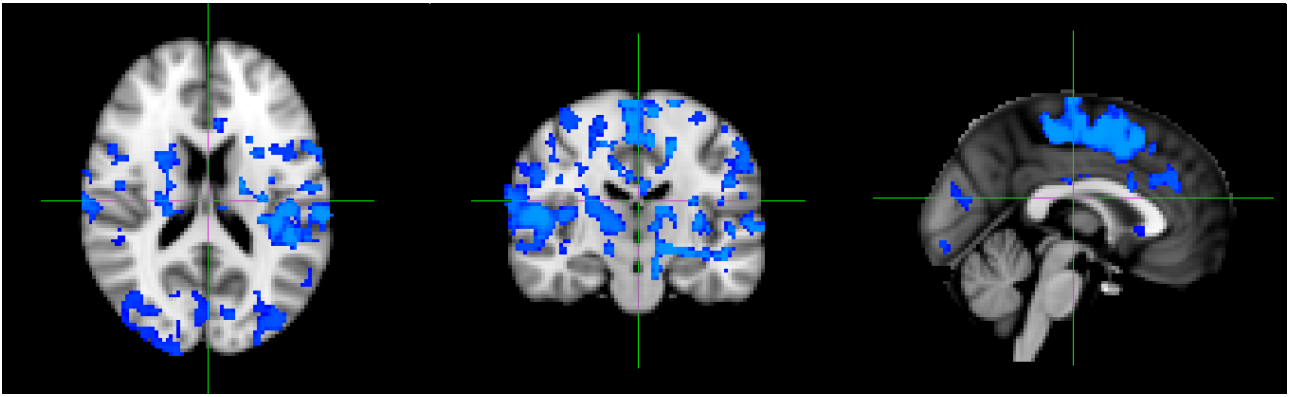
Dual regression z-maps on MRI T1 brain template (map thresholded with p value $< 0,05$). The contrast post alprazolam-pre placebo (blue color) can be seen due to an increase of connectivity. The contrast pre placebo-post alprazolam (red color) can not be seen, because results are under threshold.
